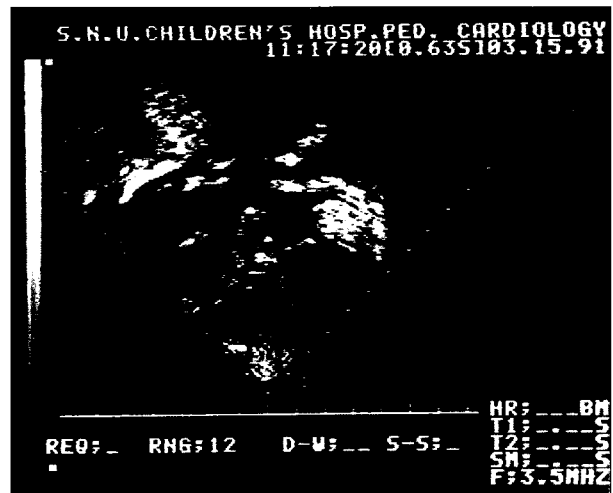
Apical four-chamber view echocardiogram in a child with lymphoma demonstrating a large echogenic mass in the right atrium with possible obstruction to the flow into the right ventricle and another echogenic mass in the interatrial septum and posterior septal wall of the left ventricle.
